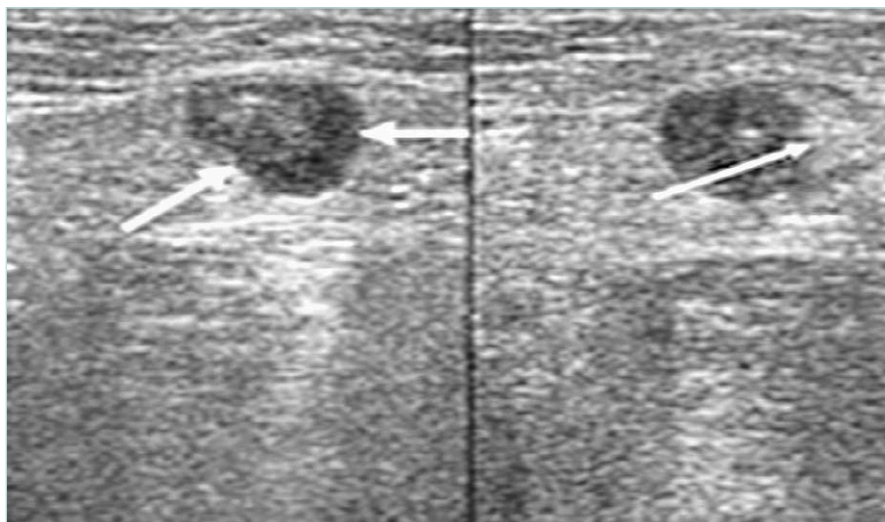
Thrombus echogenicity in ultrasonography. Deep venous thrombosis (DVT) is hyperechoic (left, white arrow), and endovenous heat-induced thrombosis (EHIT) is hyperechoic (right, white arrow).
